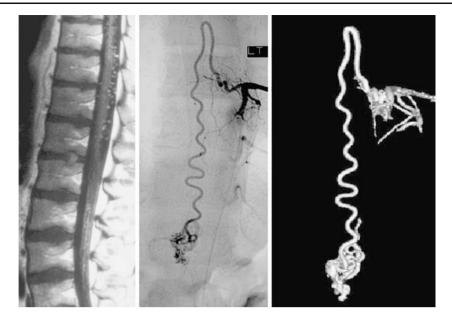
Spinal glomerular AVM: this patient presented with subacute onset of progressive weakness of both legs over a 3-month period. MRI demonstrated increased signal within the conus and multiple flow voids along the spinal cord, which enhanced with contrast.
